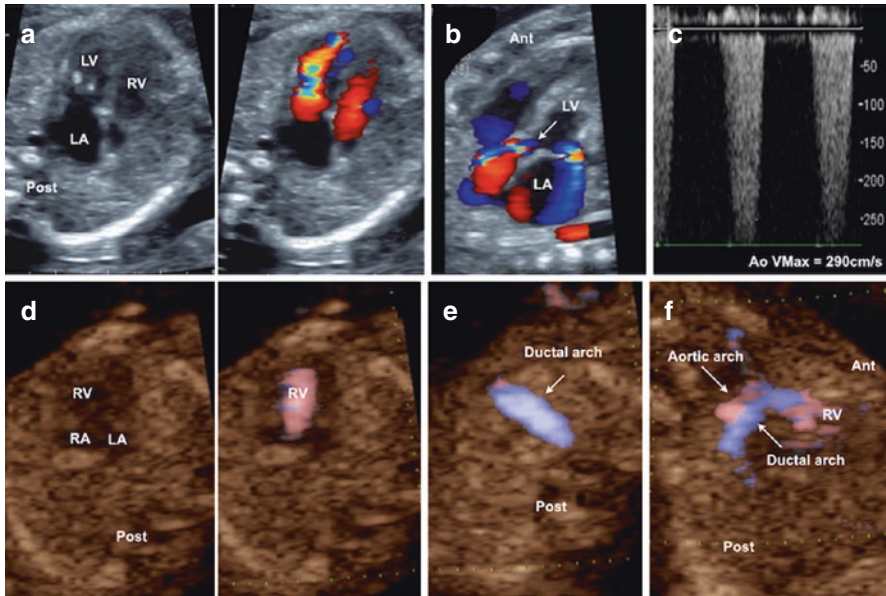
(a–c) Images obtained from a fetus at 21 weeks of gestation with critical aortic stenosis. (a) Four-chamber view in diastole on 2D (*left* panel) and colour flow (*right* panel) shows a dilated left atrium. The left ventricle reaches the cardiac apex and shows areas of hyperechogenicity. (b) Left ventricular outflow tract view in systole. Note the presence of important mitral regurgitation and a narrow jet (*arrow*) of forward flow across the aortic valve. (c) Pulsed wave Doppler shows high aortic velocity (290 cm/s, normal for gestation ~60–70 cm/s). (d–f) Images obtained from a fetus at 14 weeks of gestation with hypoplastic left heart syndrome. (d) Four-chamber view in diastole, on 2D (*left* panel) and e-flow mapping (*right* panel). Note filling of the right ventricle only. (e) Transverse view through upper mediastinum at the level of the three-vessel view. E-flow mapping shows a large ductal arch only. No aortic flow seen at this level. (f) Sagittal view demonstrates forward flow across the ductal arch and reversed flow in the transverse aortic arch. *Ant* anterior, *LA* left atrium, *LV* left ventricle, *Post* posterior, *RA* right atrium, *RV* right ventricle, *VMax* maximal velocity
